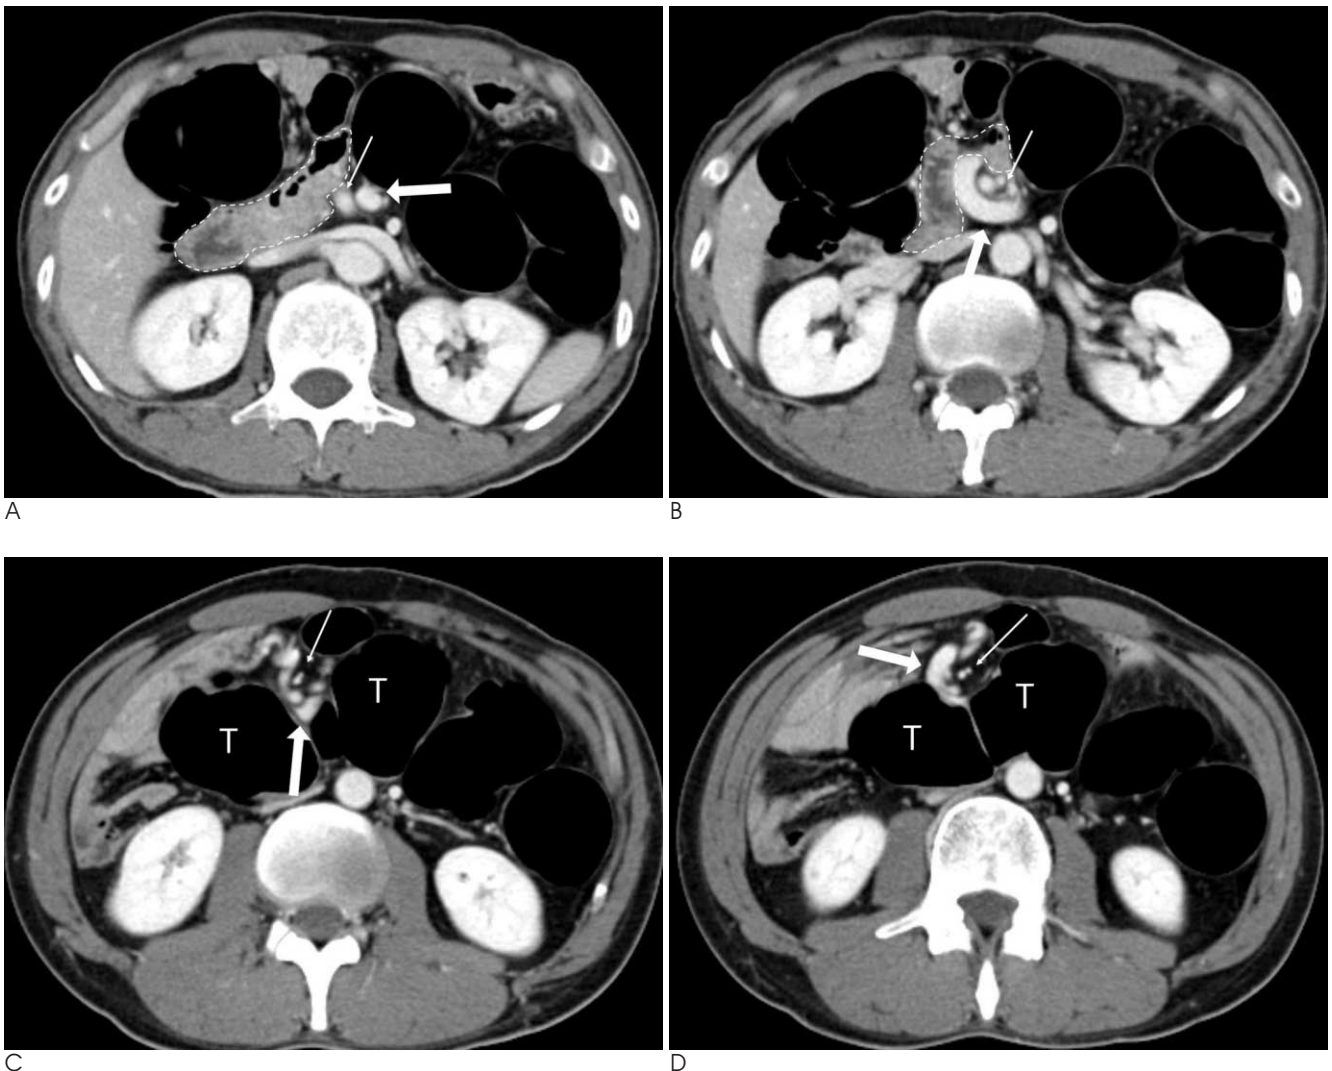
A-D. Serial axial images of a contrast-enhanced CT of a 38-year-old man with reversed rotation. SMV (thick arrow) lies to the left of SMA (thin arrow) in the first image (A), and SMV wraps around SMA clockwise on consecutive images (B-D). It is noted that the duodenum (dotted lines in A and B) cross from the right to left anterior to SMA and SMV. Images at the level of lower pole of the kidneys (C and D) demonstrate that the distended transverse colon (T) is sandwiched between the superior mesenteric vessels and the aorta.
